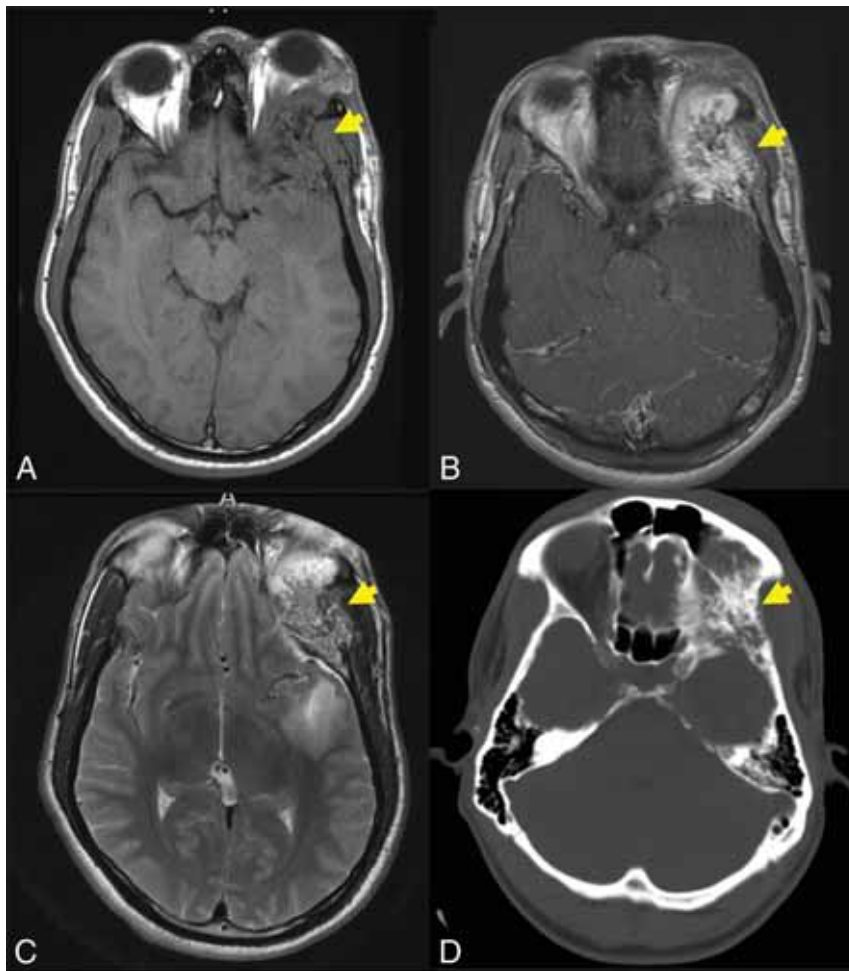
Axial T1-weighted (C) and axial T1-weighted C+ (B) demonstrate an expansile lesion centered within the left greater wing of the sphenoid, with internal T1-hypointense trabeculae and avid enhancement (yellow arrows, A and B). There is mass effect on the left orbit, with resultant proptosis. Axial T2WI (C) demonstrates that the lesion is heterogeneous but predominantly T2 hyperintense (yellow arrow, C). There is vasogenic edema in the subjacent left temporal operculum, presumably based on mass effect, a response to hypervascularity, and venous congestion. Axial CT (D) is confirmatory for the diagnosis of the IOVM, given the presence of thickened internal trabeculae (yellow arrow, D) in a characteristic pattern. The patient was treated with surgical resection. The diagnosis of IOVM was confirmed on pathology, which showed dilated thin-walled blood vessels distending and replacing medullary bone. C+ indicates with contrast. Case courtesy of Phillip Chapman, MD, Professor of Radiology, Duke University School of Medicine.
